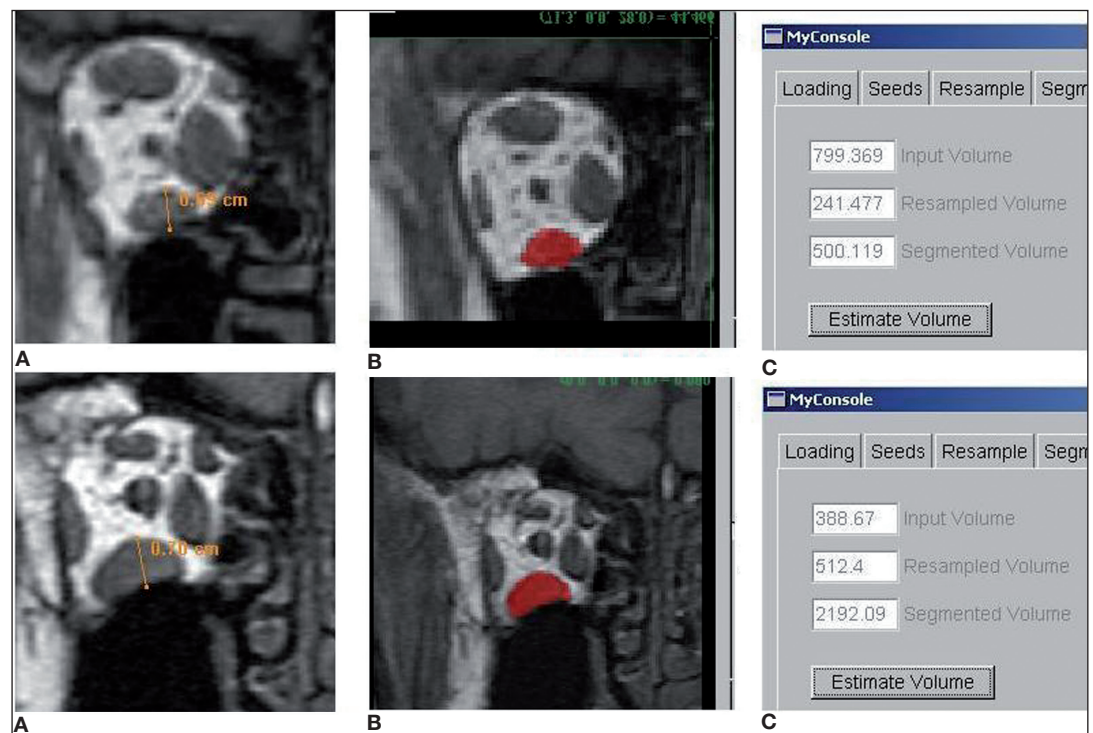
An example of two patients with the identical vertical diameter of inferior rectus muscles (IM) (6.9–7.0 mm) and significantly different volumes of these muscles (A) taking the vertical diameter of IM using a DicomWorks application, (B) covering an area of interest on the muscle section on MR images in Z plane using the NSI technique, (C) the results: for Patient 1 500.19 mm³, for Patient 2 2192.09 mm³.
